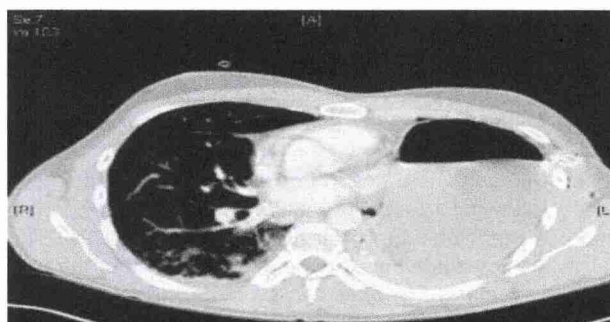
CT scan of Diaphragmatic injury
